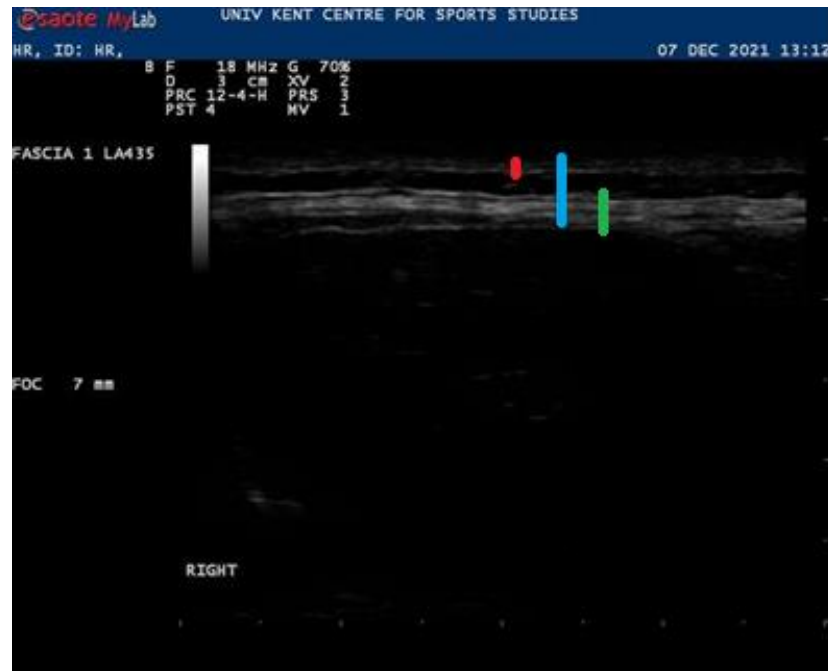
Ultrasound imaging of the thoracolumbar fascia of an individual without LBP.
